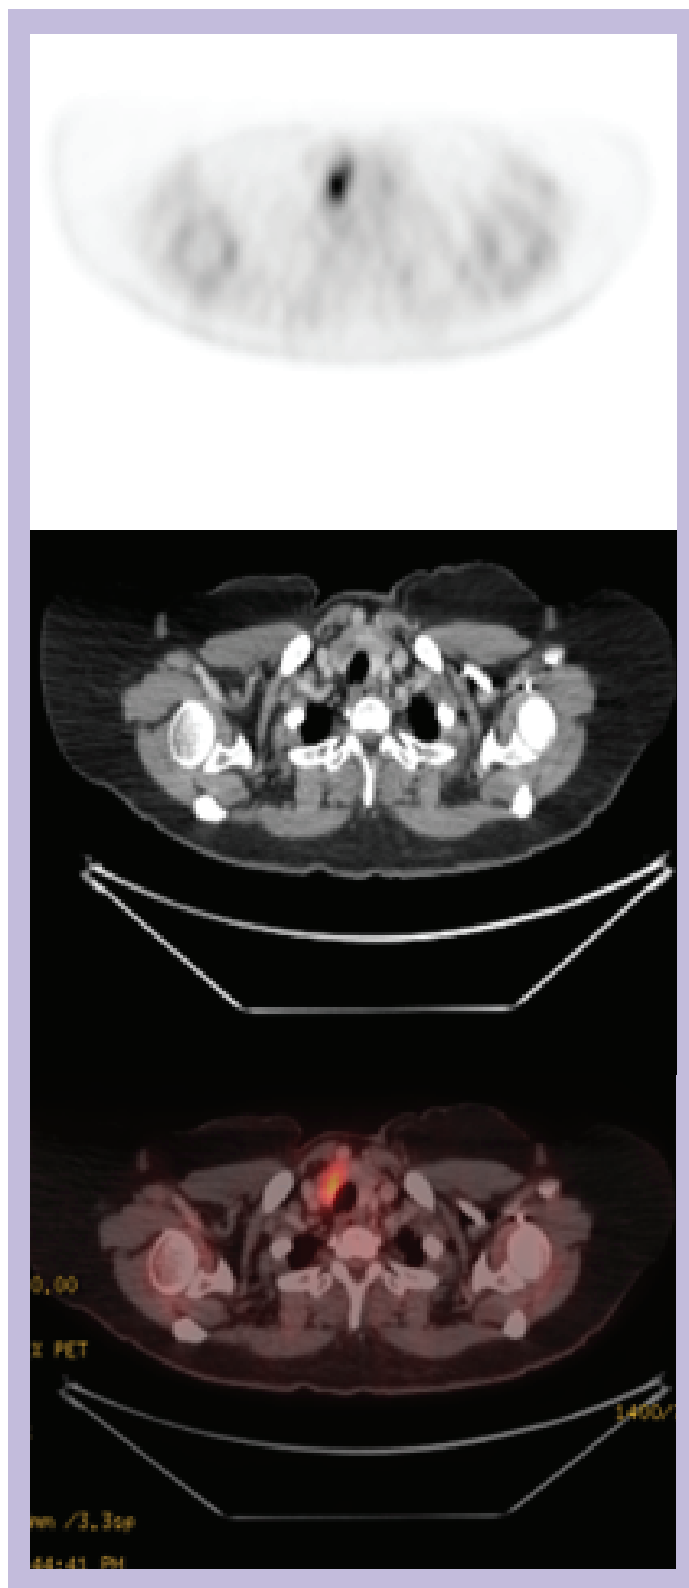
axial slices PET, CT and fused PET/CT images (top to bottom) showing the focal FDG avid hypodense nodule in right thyroid lobe (SUVmax – 5.9).
